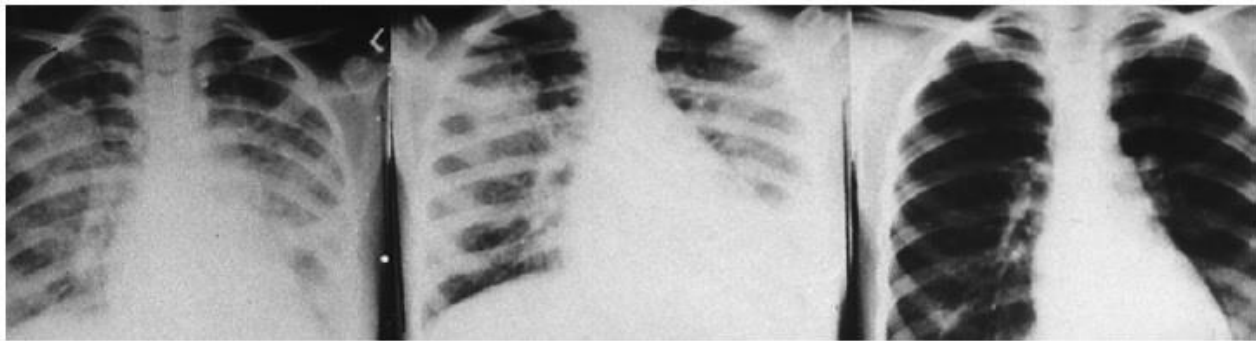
Serial chest radiographs demonstrating the resolution of pulmonary edema (left to right).
